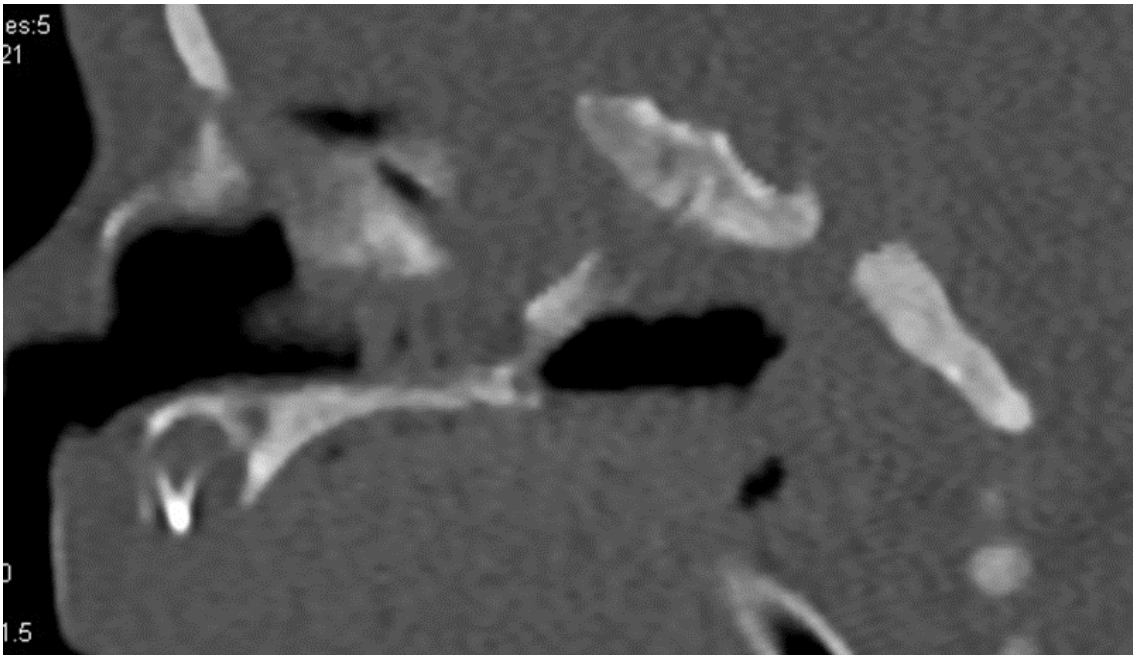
CT scan: Computerized tomography image in sagittal plane with bone window of a patient presenting with bilateral choanal atresia, revealing a mixed bony and membranous component
